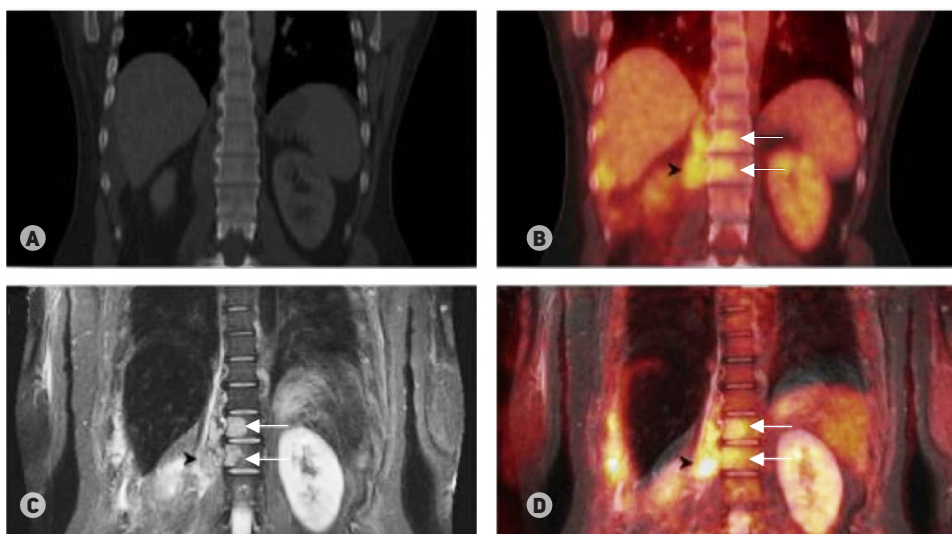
Non-Hodgkin lymphoma spread to the bone marrow. Computed tomography in the bone window (A) detects paravertebral tumor masses, but does not see lesion-infiltrated vertebrae, while magnetic resonance imaging (C) can detect these lesions (shown by arrows) confirmed by hybrid technologies: PET-CT (B) and ^{18}F -fluorodeoxyglucose-enhanced PET-MRI (D). Thus, MRI is more sensitive in the diagnosis of bone marrow lesions and detects the first signs of bone destruction and plasma cell infiltrates before osteoclast hyperstimulation can be observed (Buchender et al. [24])
